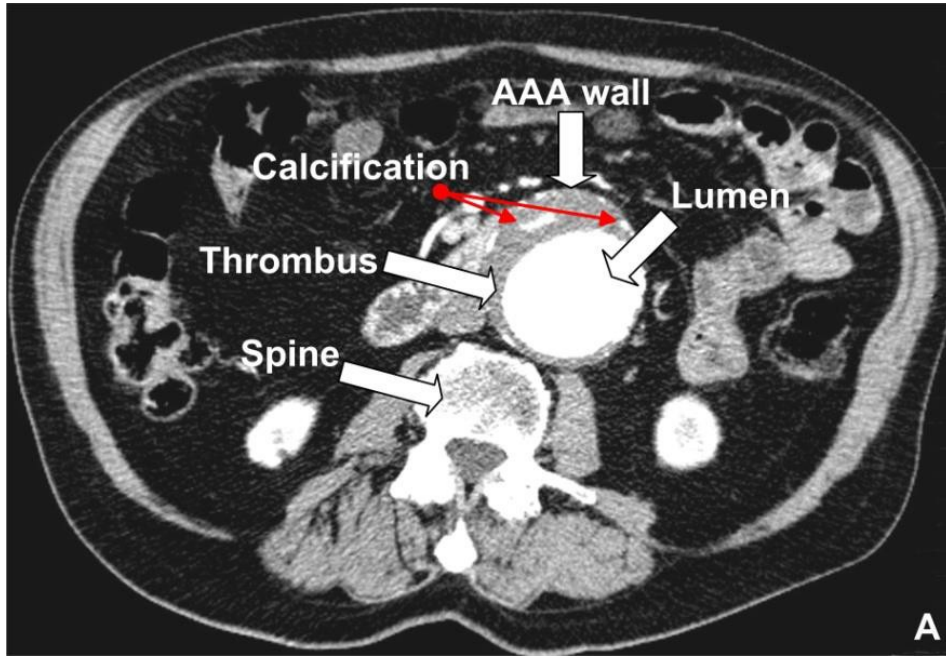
CT scan identifying the AAA lumen, wall, calcification, thrombus [79].
